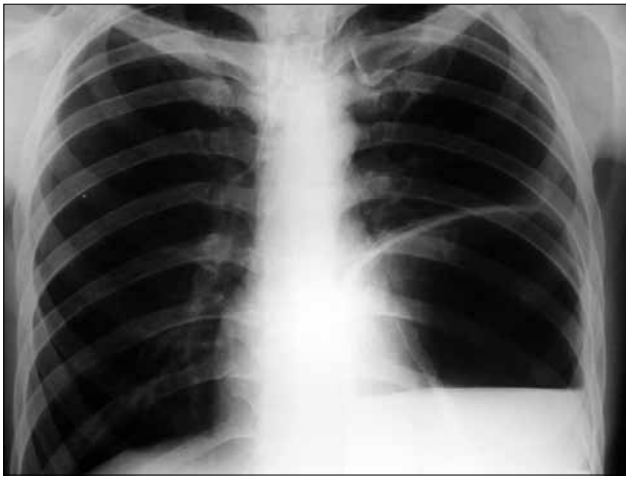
Chest radiography showing a dilated gastric shadow with a fluid level.
